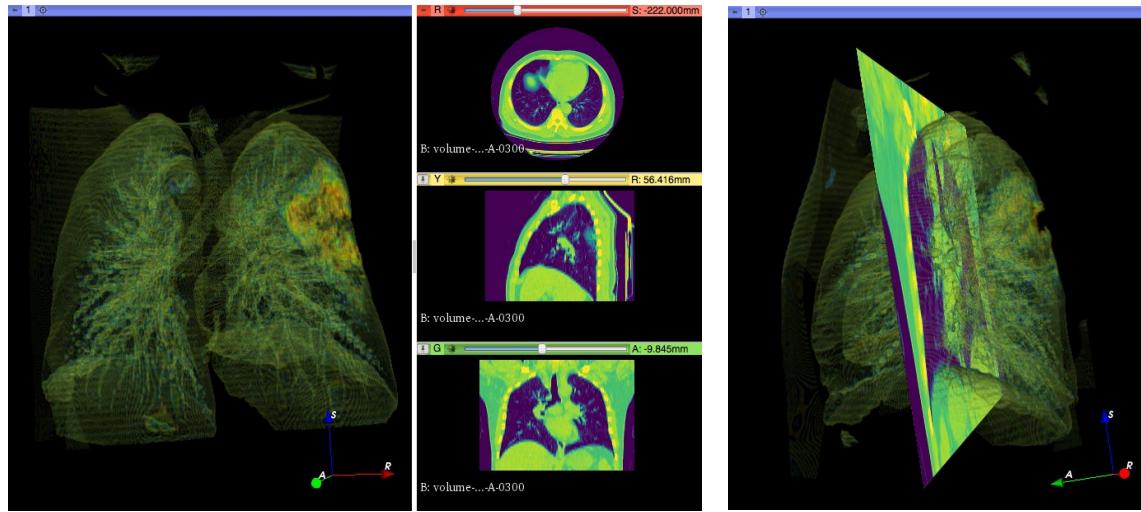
COVID Patient 300 Lung CT Scan: 2D, 3D, and Sliced Rendering Using 3D Slicer
